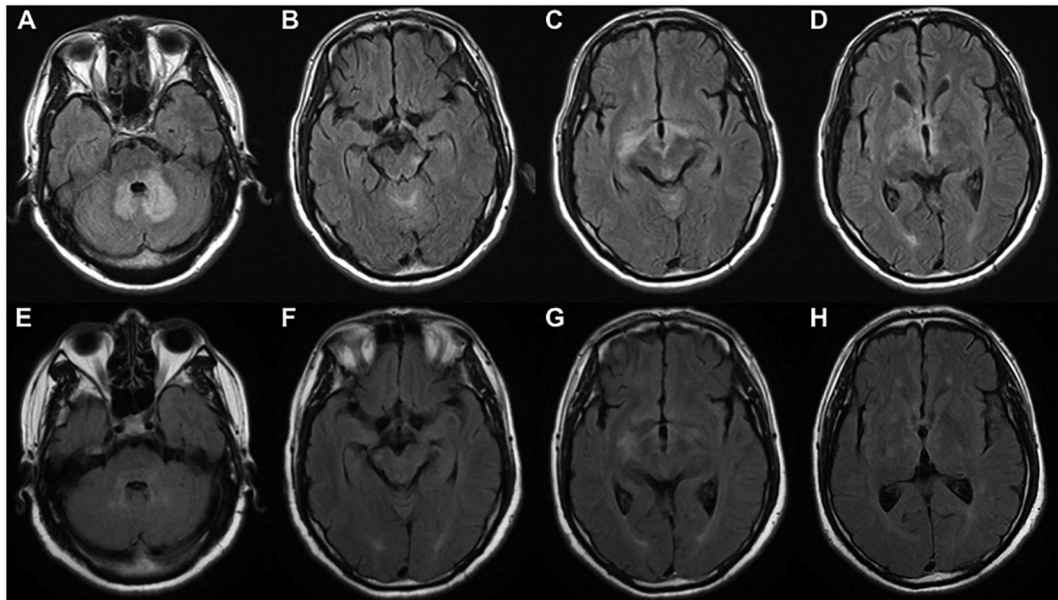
Brain magnetic resonance imaging of the patient. The upper row (A–D) showed patient's T2-weighted fluid-attenuated inversion recovery (FLAIR) imaging of the brain before the immunosuppressant treatment. There were multi-lesions in the brain, including extensive dorsal brainstem lesion involving the bilateral cerebellum, right cerebral peduncle and the brain parenchyma surrounding the third ventricle. The lower row (E–H) showed FLAIR imaging after one and half a month of immunosuppressant treatment. These slides suggested that lesions in brainstem, bilateral cerebellum and brain parenchyma surrounding the third ventricles have been almost resolved.
